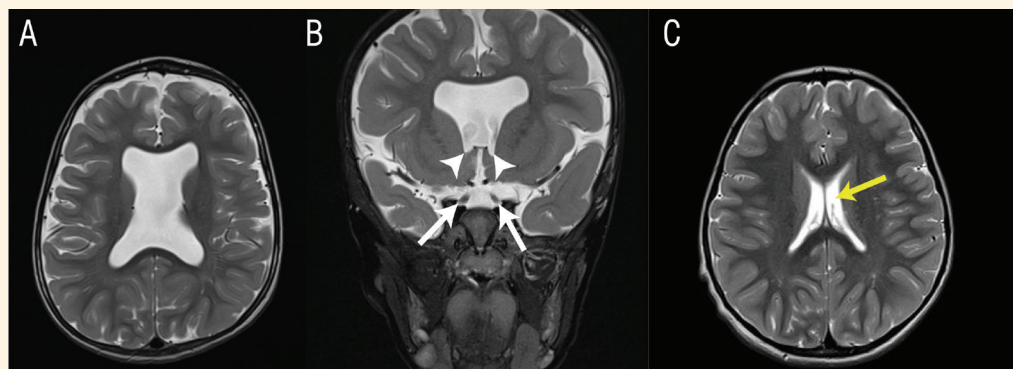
A: Magnetic resonance imaging of the brain of the patient at 33 months of age showing absence of the *septum pellucidum* in an axial T2-weighted image. B: Coronal T2-weighted image showing squaring of the frontal horns with inferior pointing (arrowheads). The pre-chiasmatic segments of the optic nerves are bilaterally visible with normal size (arrows). C: An axial T2-weighted image from another patient showing normal *septum pellucidum* (yellow arrow).
